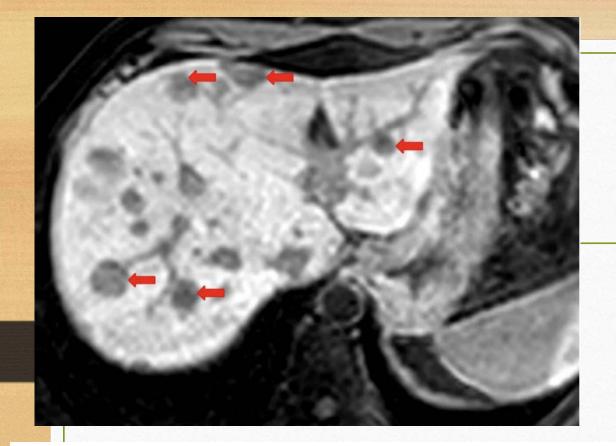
Axial unenhanced T1-weighted MR image of a patient with Caroli disease, showing multiple hypointense cystic structures (arrows), corresponding to saccular dilatations of the biliary tree.
